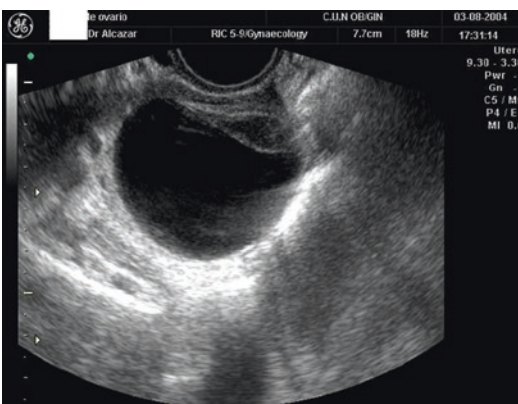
Transvaginal ultrasound depicting an ovarian endometrioma as an anechoic cyst, some debris can be seen in the bottom of the cyst cavity
